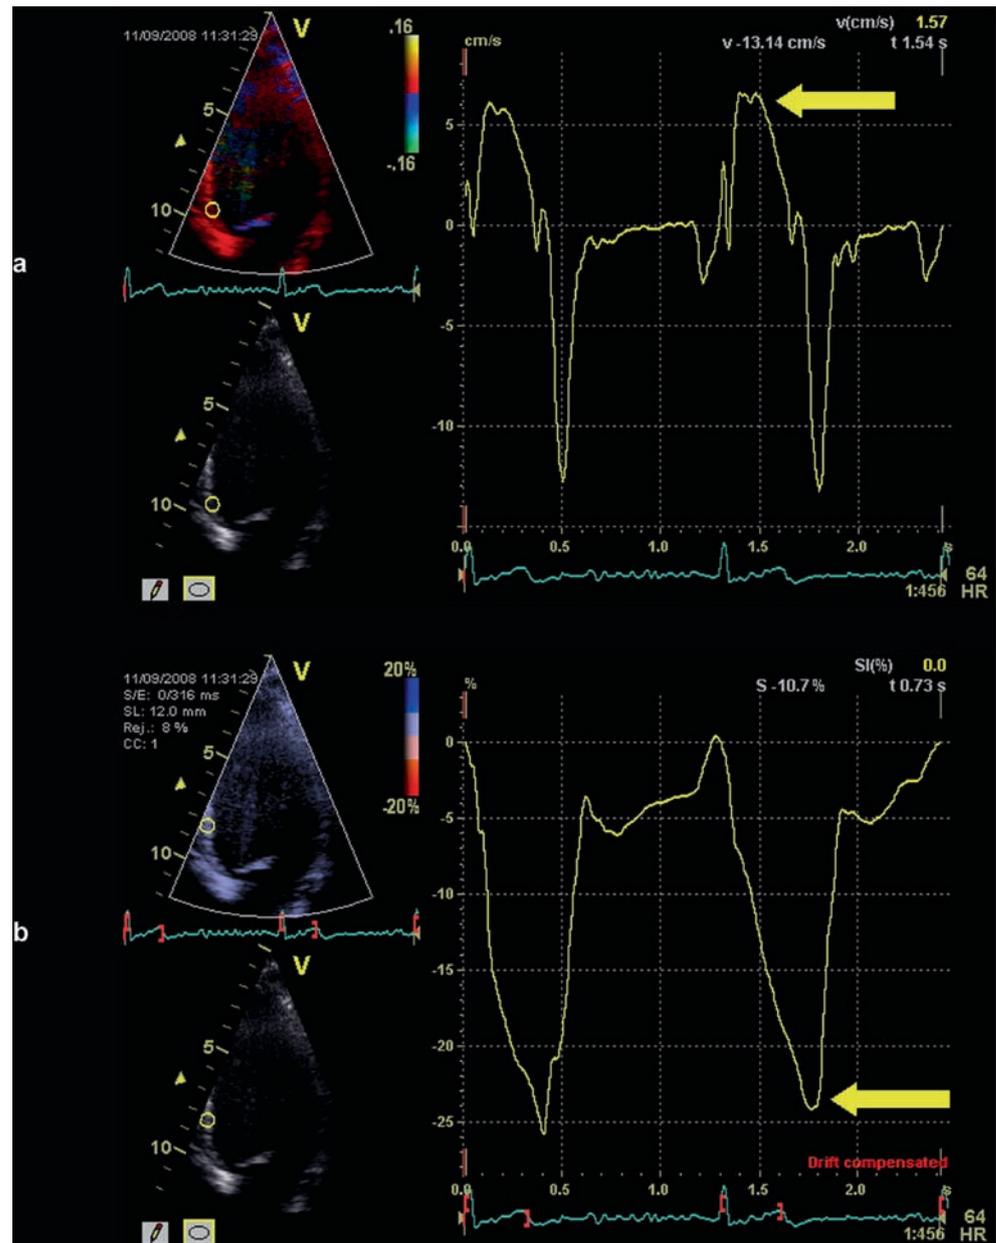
(a) Identification of peak myocardial systolic velocity (*arrow*) in a tissue Doppler-derived velocity curve. (b) Identification of peak longitudinal (negative) strain (*arrow*) in a tissue Doppler-derived strain curve
